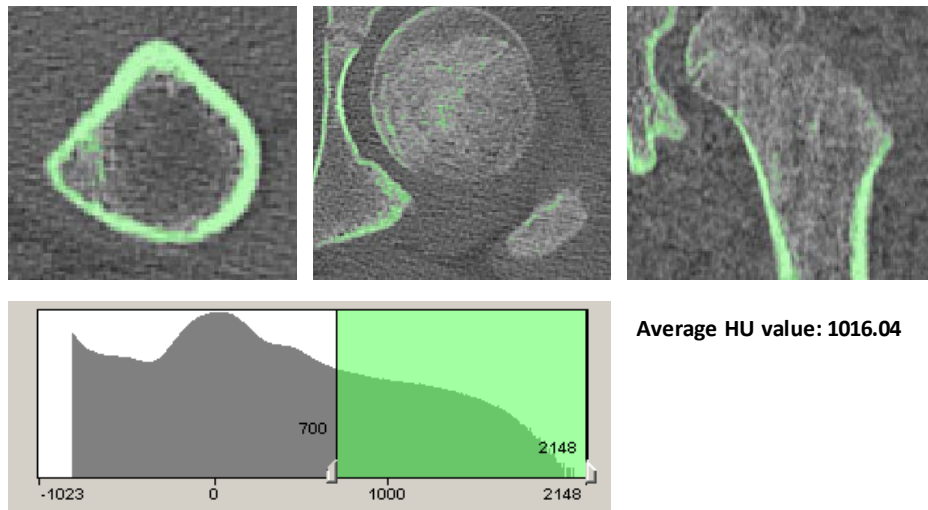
Three radiographic slices indicate the cortical bone mask threshold region (green), ranging from $HU=700-2148$. The average HU value of the cortical bone mask is 1016.04.
